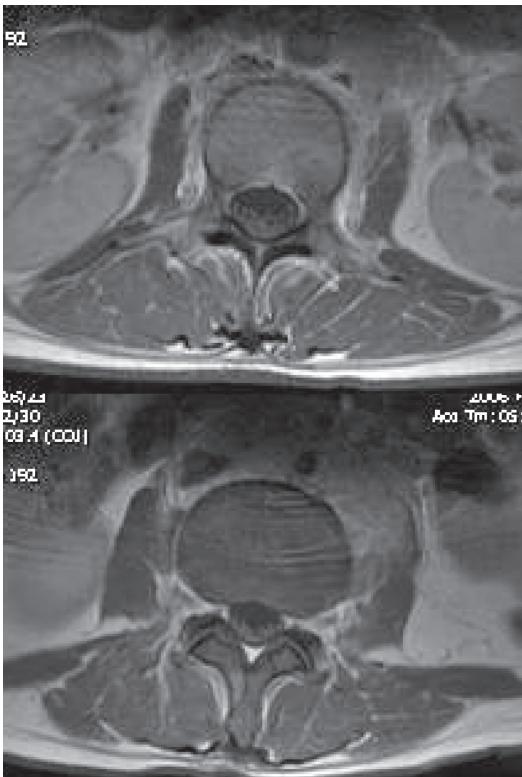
Axial plane T1-weighted MRI of cauda equina after injection of gadolinium showing thickening and clumping of cauda equina nerve roots representing radiculitis
